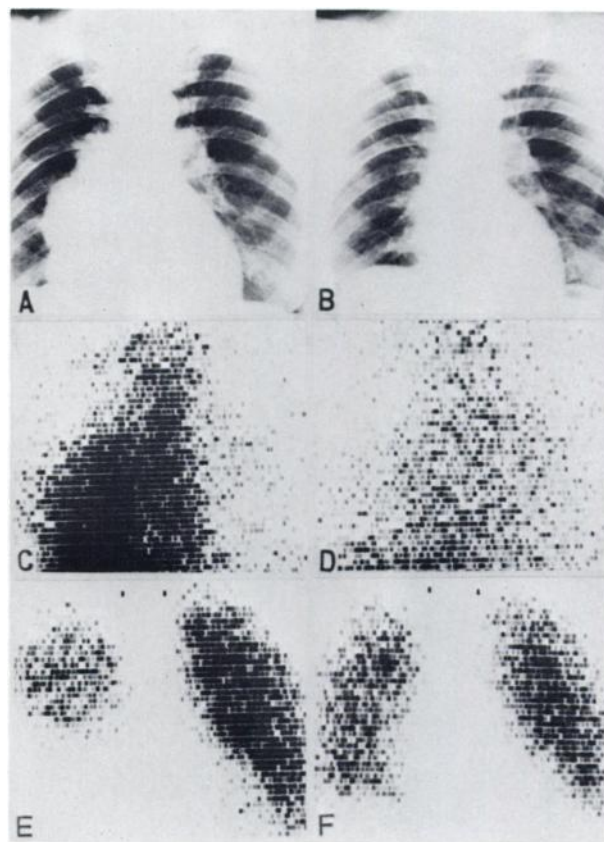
(A) Chest x-ray shows large shadow along margin of heart in right lower lung field. (C) Scintigram with ^{67}Ga -citrate is strongly positive. (E) Pulmonary scanning with ^{131}I -MAA shows defect in middle and lower lung fields. (B,D,F) Abnormal shadow in chest x-ray and scintigram almost disappeared and returned to normal after treatment.
